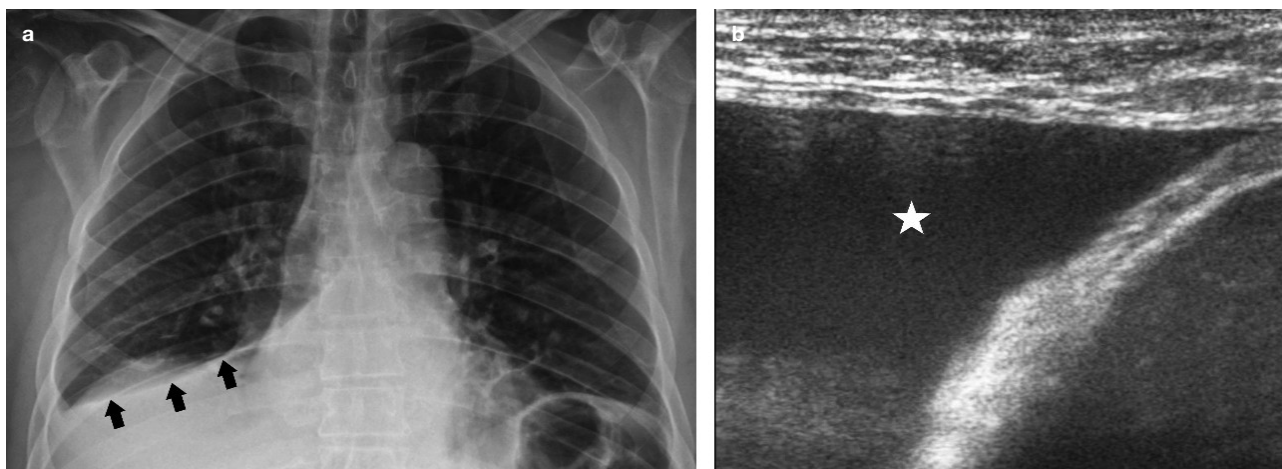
In patients with suspected hemothorax, US is helpful in determining the characteristics (free flowing or loculated) and localization of pleural fluid. Chest X-ray of subpulmonary hemothorax (arrows) is shown in “a”. In the lung US of the same patient, pleural fluid (asterisk) located in the costophrenic sinus is seen.
